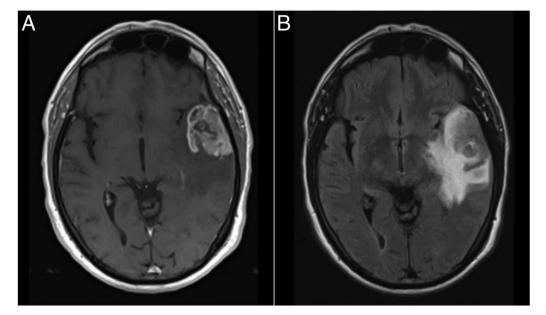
Preoperative brain MRIs. (A) Gadolinium-enhanced T1-weighted axial image showing a lesion in the left temporal lobe with heterogeneous contrast uptake. (B) Fluid-attenuated inversion recovery axial image showing tumoural infiltration/oedema in the surrounding brain parenchyma.
